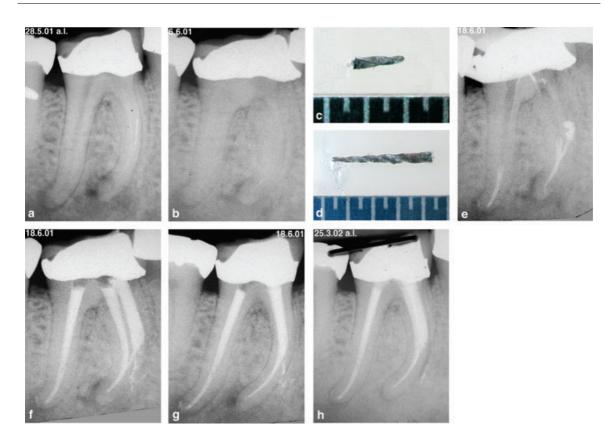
(a) Two fractured instruments: GT Rotary 20.06T in mesiolingual canal and GT Rotary 20.08T in mesiobuccal canal of a mandibular right first molar. (b) Instruments removed: success mesiolingual, failure mesiobuccal because of perforation. (c) Instrument removed from mesiobuccal canal after bypassing with hand instruments: removal time: 15 min. (d) Instrument removed from mesiobuccal canal using ultrasonics: removal time: 2 h; perforation. (e) Mesiobuccal canal was no longer negotiable after perforation but was obturated when downpacking the mesiolingual canal. (f) The perforation was obturated when backpacking the mesiobuccal canal, ledge formation is also evident. (g) Final radiograph. (h) 9-month recall: tooth is symptomless.
